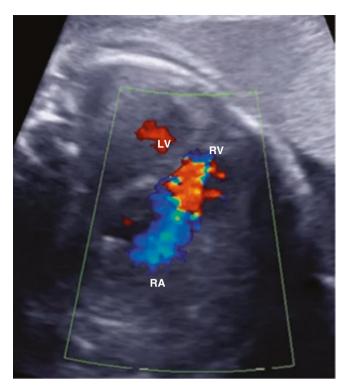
Fetal echocardiogram showing four-chamber color flow Doppler of the severe tricuspid insufficiency arising from the displaced Ebstein's anomaly of the tricuspid valve in the right ventricle (RV) and entering the dilated right atrium (RA). LV left ventricle
